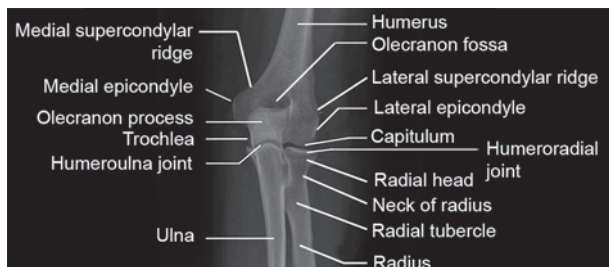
X-ray showing skeletal land marks around elbow joint
